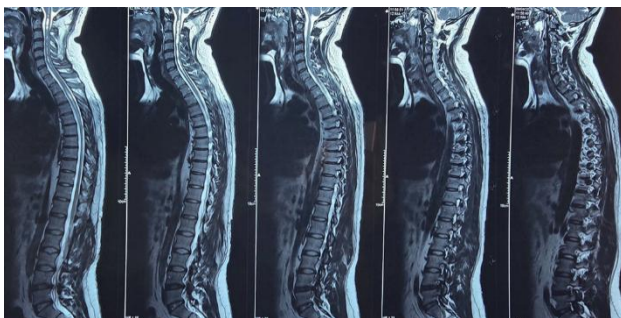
post op MRI of the spine done 6 months later
